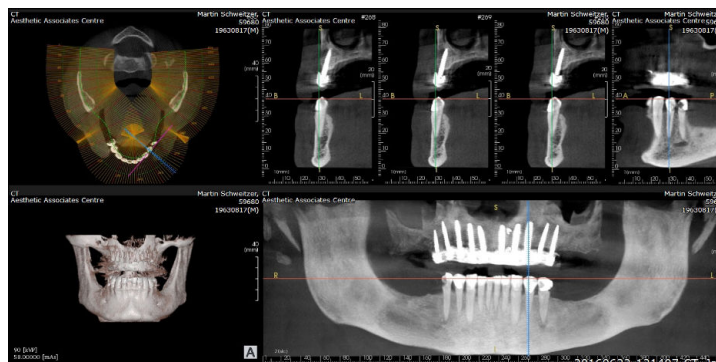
CBCT scan from consult.
